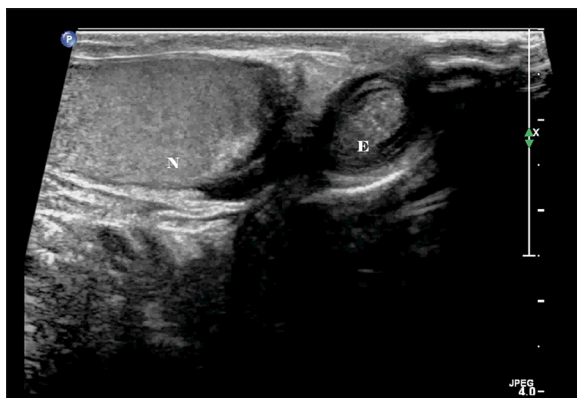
40-year-old man with polyorchidism. Vertical ultrasonography image of normal testis (N) and extra testis (E). In this image the extra testis is situated inferiorly to the left testis. The scattered microlithiasis foci are seen as submillimetric echogenities.
